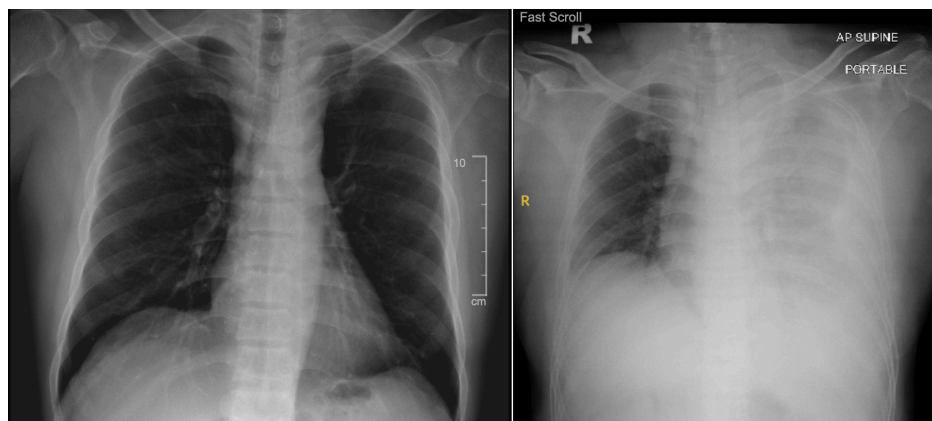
(Left) Pre-procedure and (right) post-procedure chest X-ray.
